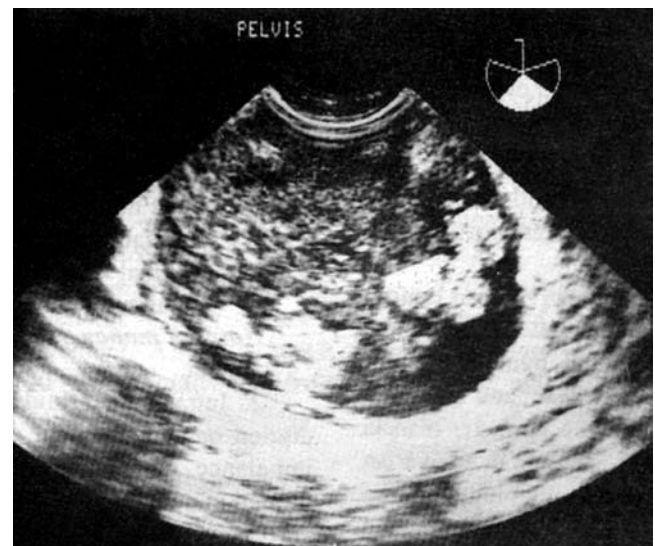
Ultrasound showing pelvic abscess.
